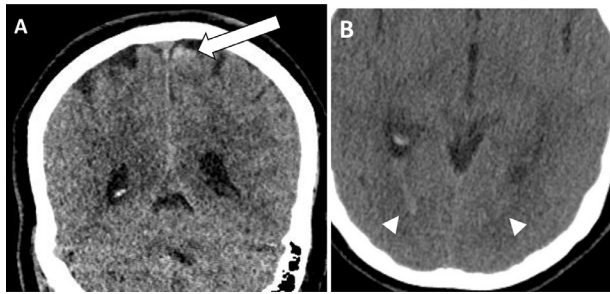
(A) Coronal noncontrast head computed tomography reveals trace subarachnoid hemorrhage over the left parietal lobe (white arrow). (B) Axial reconstructed image shows intraventricular hemorrhage in the occipital horns of lateral ventricles (arrow heads).
